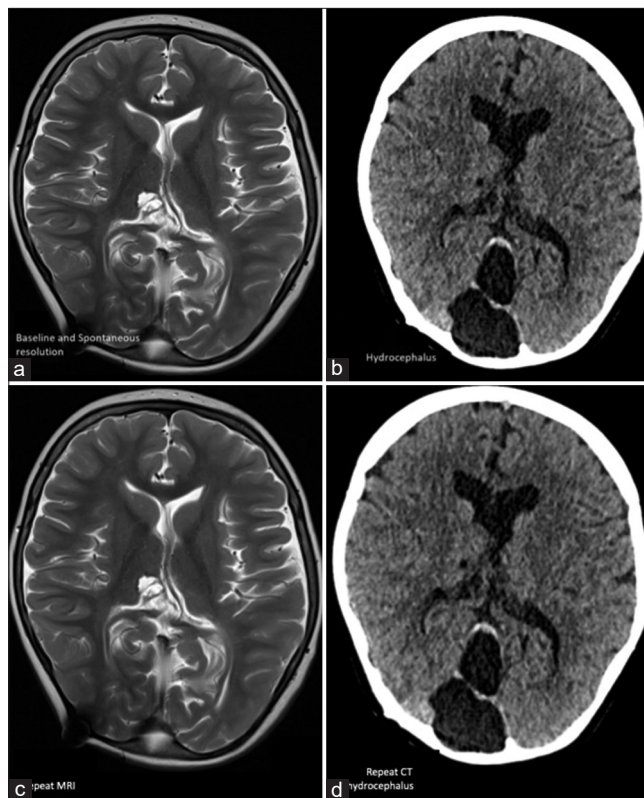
(a) Baseline noncontrast axial T2 magnetic resonance imaging (MRI) demonstrating baseline ventricle size. (b) Noncontrast axial computed tomography (CT) in a 4-year-old boy with known ventriculoperitoneal shunt demonstrating acute hydrocephalus and increased ventricle size when compared with his baseline. (c) Repeat MRI on the morning of the scheduled OR demonstrating spontaneous resolution of hydrocephalus coinciding with symptomatic improvement. (d) Noncontrast axial CT performed a few weeks later demonstrating acute hydrocephalus.
